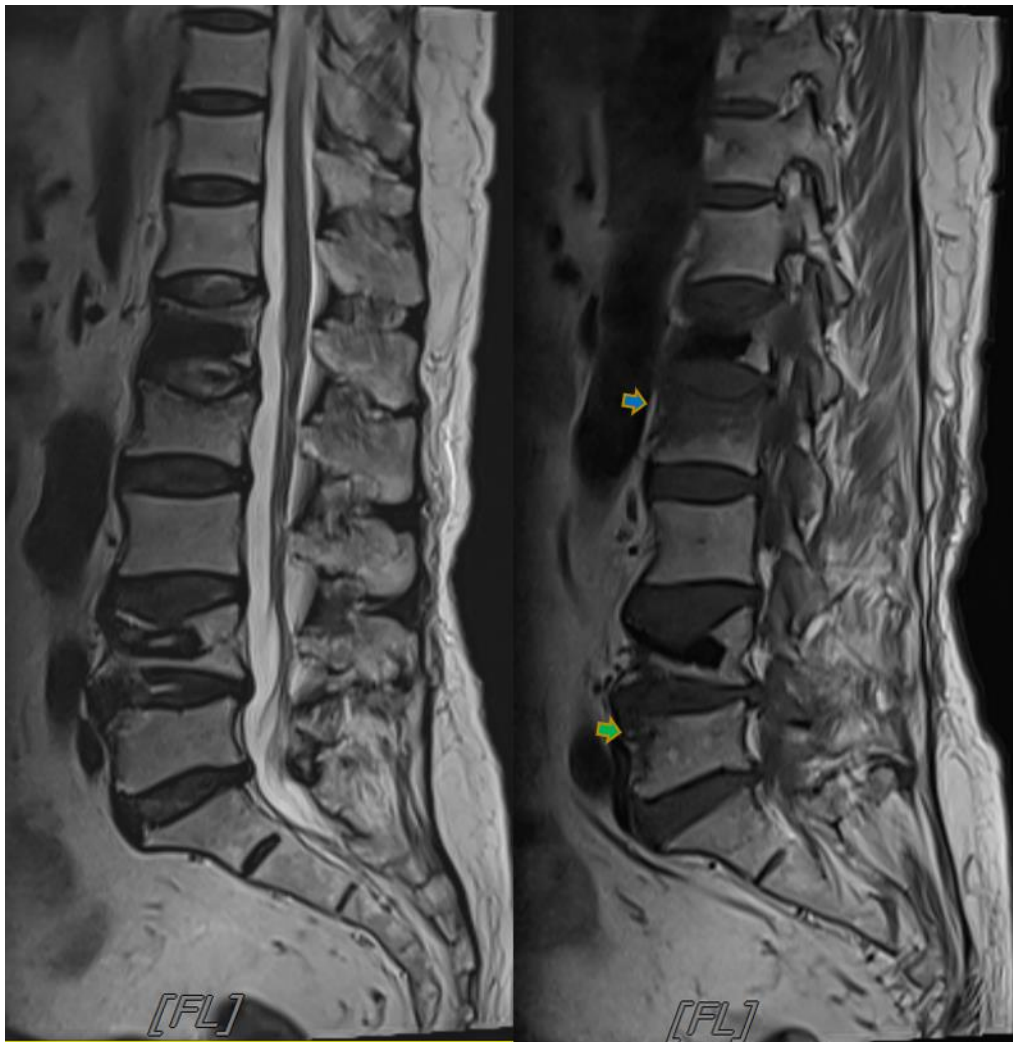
New L-spine MRI taken on September 3rd. A parasagittal T2 & T1-weighted images show a compression fracture with bone marrow edema, suggestive of recent fracture, at L2 vertebra (Blue arrow) and suspicion of compression fracture at anterior portion of L5 vertebra (Green arrow)
